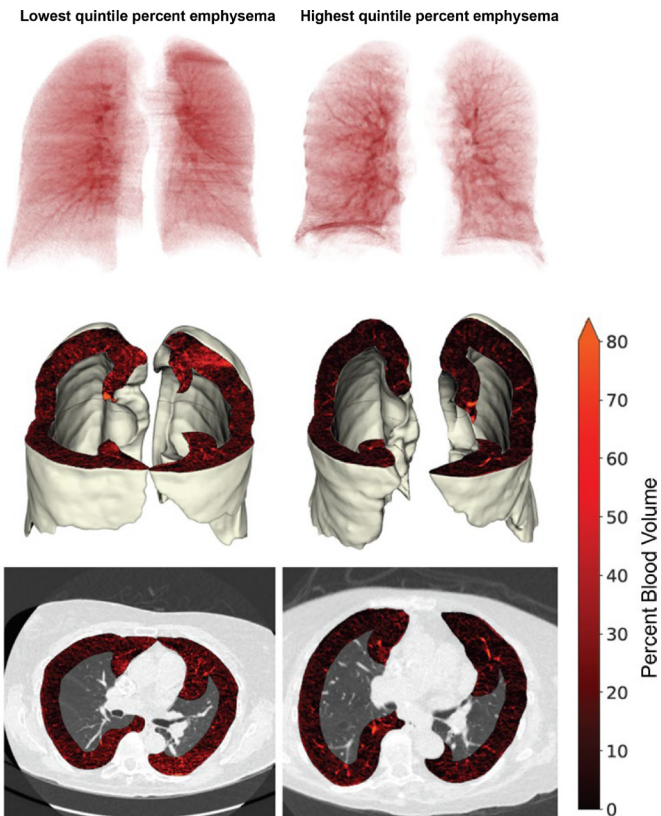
Contrast-enhanced, dual-energy CT (DECT) scans showing pulmonary blood masks and three-dimensional and two-dimensional reconstructions of pulmonary microvascular blood volume in representative participants with low and high per cent emphysema. Participants from the lowest and highest quintile per cent emphysema are shown. Pulmonary microvascular blood volume, or volume of blood in the peripheral 2 cm peel of lung parenchyma, is demonstrated in red on pulmonary blood volume maps (top) and on three-dimensional reconstructions of the lungs (middle), and axial two-dimensional sections (bottom) of DECT images. Participants are female non-smokers with age and body mass index within 1 SD of the population mean.
